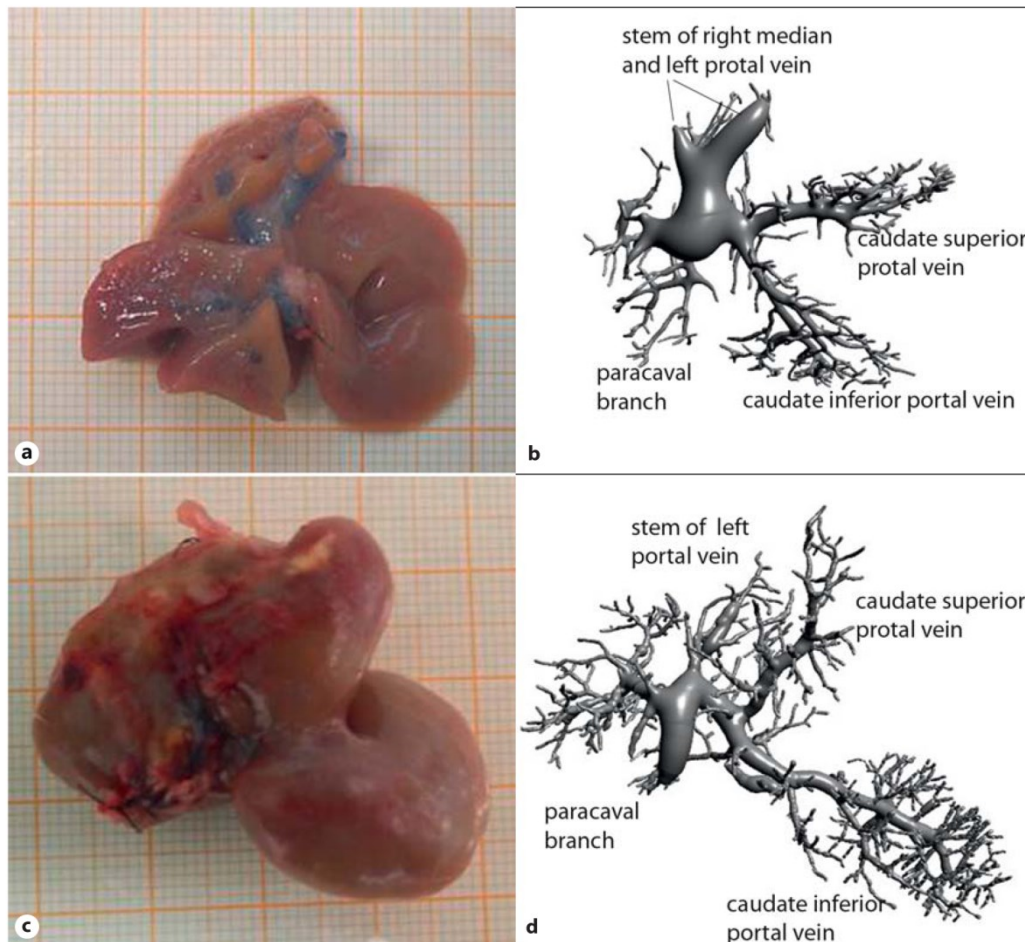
Macroscopic appearance of a remnant liver after 90% PHx on day 0 (a) and on day 14 (c). 3D reconstruction of a hepatic portal vein from a Microfil CT scan after 90% PHx on day 0 (b) and on day 14 (d).
